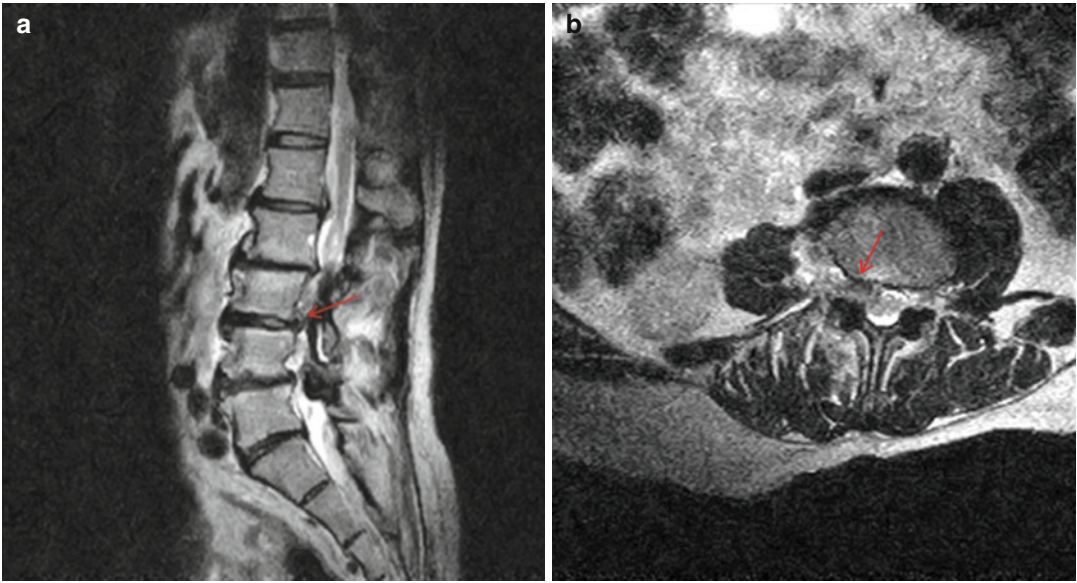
(a) Right-sagittal T2-weighted MRI scan of a 73-year-old male presenting with right L3 radiculopathy with associated quadriceps weakness with 3-day relief after a L3–4 transforaminal steroid injection. *Red arrow* denotes right sided L3–4 foraminal disc herniation. (b) Axial T2-weighted MRI image portraying right L3–4
